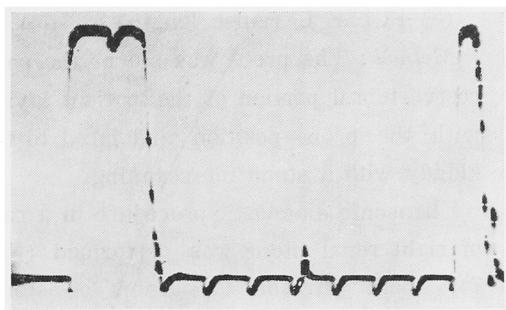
Ultrasono-echogram of Stone (D) Hanging in Water.
